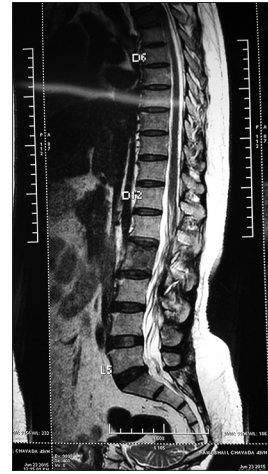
Magnetic resonance imaging spine showing wedge compression in D4 and L2 vertebra suspicious of metastases
